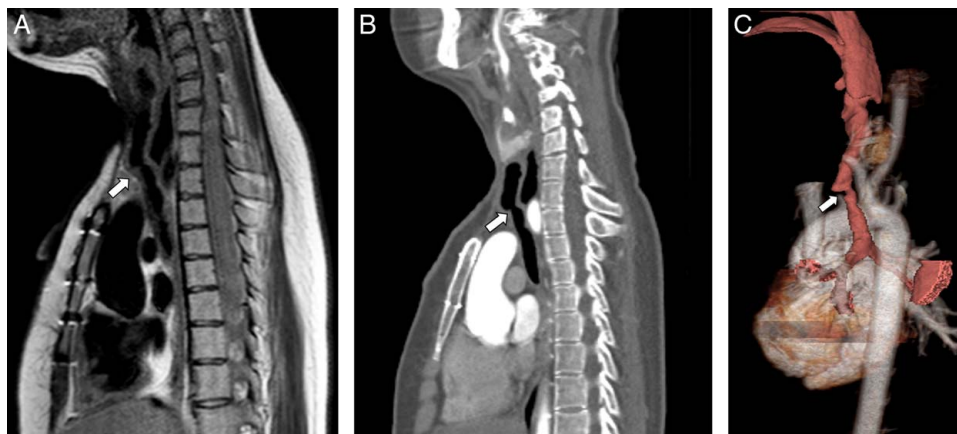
A 18-year-old male with tracheal stenosis. A, Sagittal nonenhanced T1-weighted MR image shows tracheal narrowing (arrow). B, Sagittal enhanced soft tissue window setting CT image shows tracheal narrowing (arrow). C, 3D reformatted CT image of the airway and vascular structures shows tracheal narrowing (arrow).
